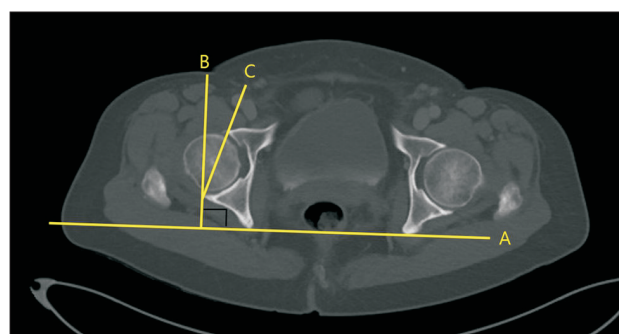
Computed tomography through the center of the femoral head. Line A is a line connecting both ischial spines. Line B is a perpendicular line to line A. Line C is a line connecting the acetabular anterior and posterior edges. The angle between line B and lines C was defined as the acetabular anteversion.
